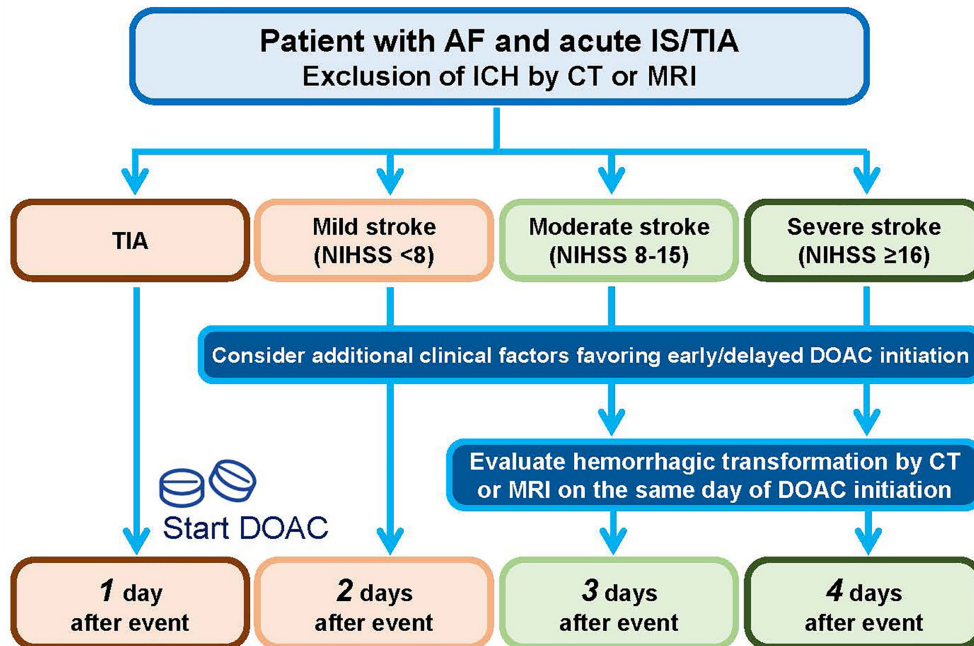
(Re-) initiation of anticoagulation after transient ischaemic attack/stroke. (Re-) start only in the absence of contraindications and if stroke size is not expected to substantially increase the risk of secondary haemorrhagic transformation. *Consider shorter delays to (re-) start a non-vitamin K antagonist oral anticoagulant if there is a very high risk of stroke recurrence (e.g. left atrial appendage thrombus) and no haemorrhagic transformation on follow-up brain imaging (using computed tomography or magnetic resonance imaging). Consider longer delays to (re-)start a non-vitamin K antagonist oral anticoagulant according to the recommendations made in the European Society of Cardiology Atrial Fibrillation Guidelines 2016. #Without proven evidence; consider inclusion of patient in an ongoing trial.
